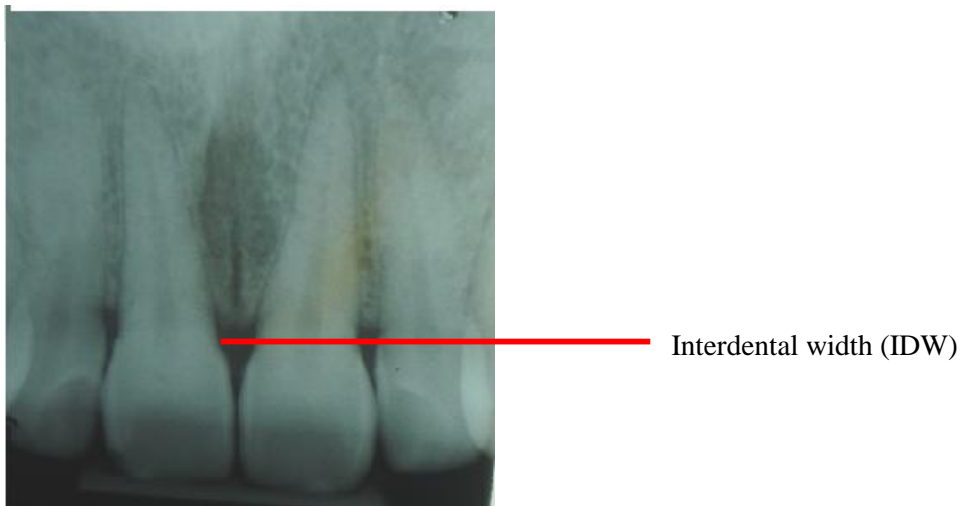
shown the horizontal distance measured from periapical x-ray: Interdental width (IDW)
